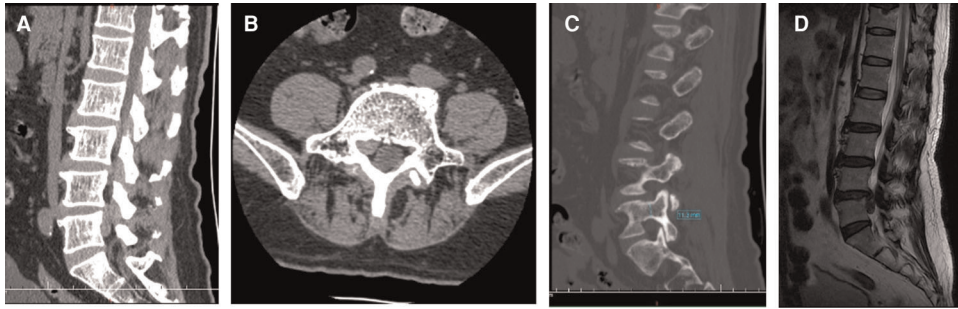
(A) Computed tomography scan shows that the distal end of the prolapsed nucleus pulposus is downward beyond the inferior margin of the L5 pedicle. (B) Computed tomography scan shows the migrated nucleus that compressed the nerve root. (C) The measurement of the pedicle height is 11 mm. (D) The magnetic resonance imaging shows that the migrated herniation can be classified into type 4 according to Lee's classification.
